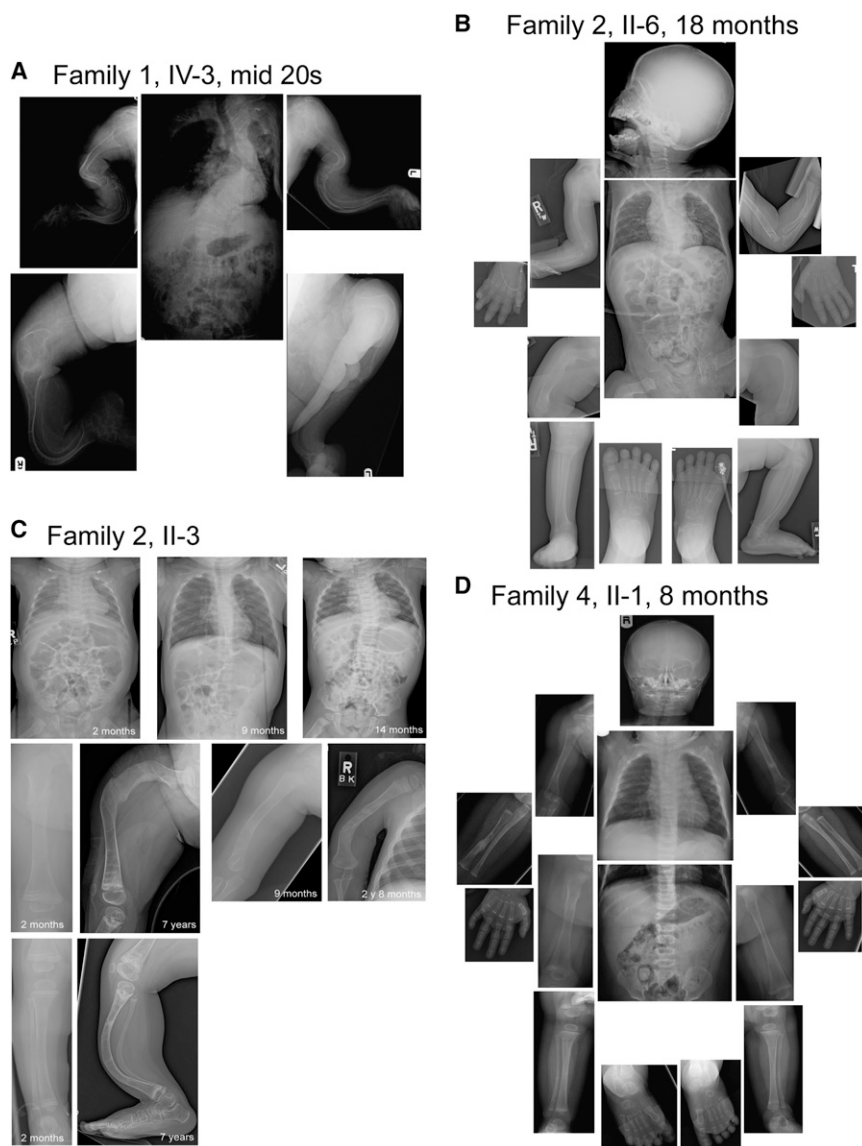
Radiographs of Affected Individuals with *WNT1* Mutations
